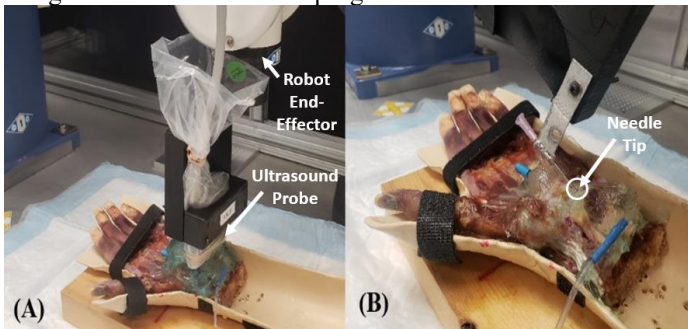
Robot assisted ultrasound scanning (A) and needle injection (B)
